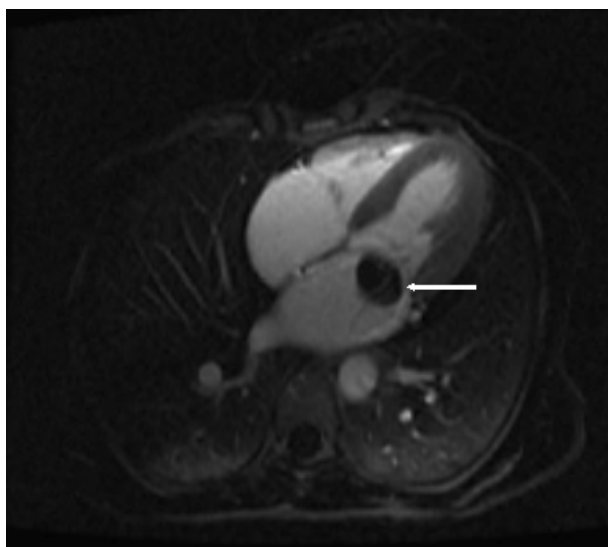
MRI 4 chamber view. The arrow points to the Aspergilloma on the mitral valve.
